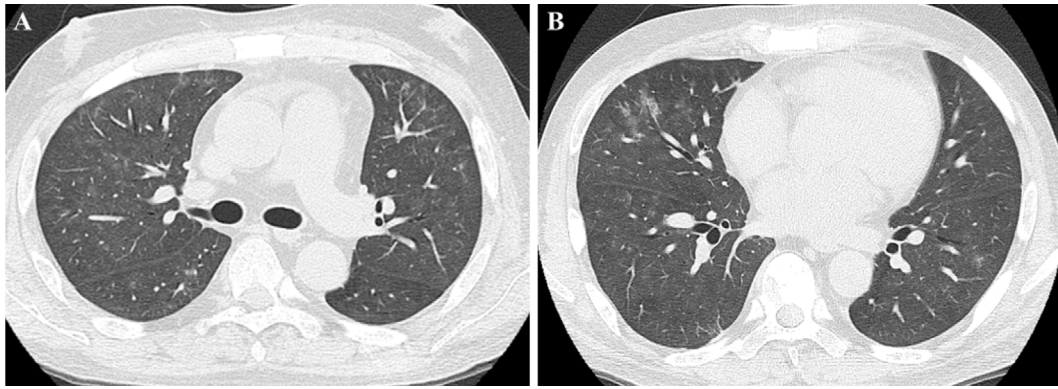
Chest CT on admission showing multiple ground-glass opacities in both lungs.
